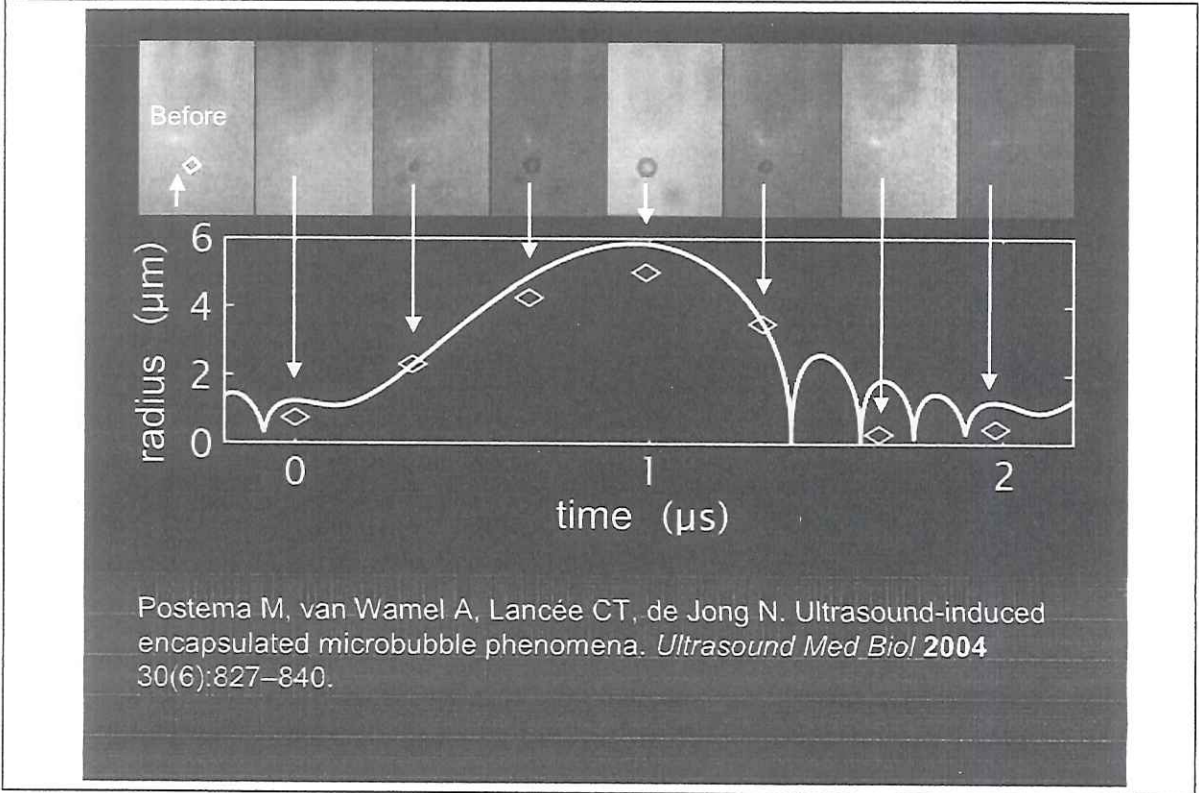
Oscillating experimental contrast microbubble. The image sequence spans one ultrasonic cycle. The first frame has been captured prior to ultrasound arrival. Inter-frame times for the other frames are  $0.33 \mu\text{s}$ . Each frame corresponds to a  $88 \times 58 \mu\text{m}^2$  area. Above: a  $\varnothing 1.5 \mu\text{m}$  bubble strongly oscillates ( $MI=0.67$ ). Below: radius–period plot of the event. The solid line represents an oscillating free gas bubble.
